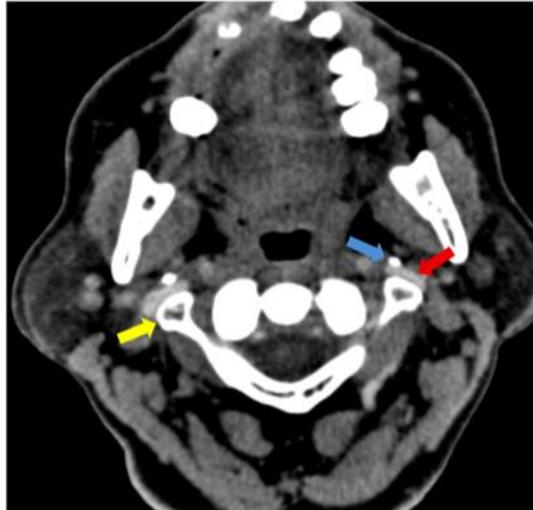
Axial CT images showing the compression of both internal jugular veins (red arrow) between the styloid processes (blue arrow) and transverse processes of C1 (yellow arrow)
